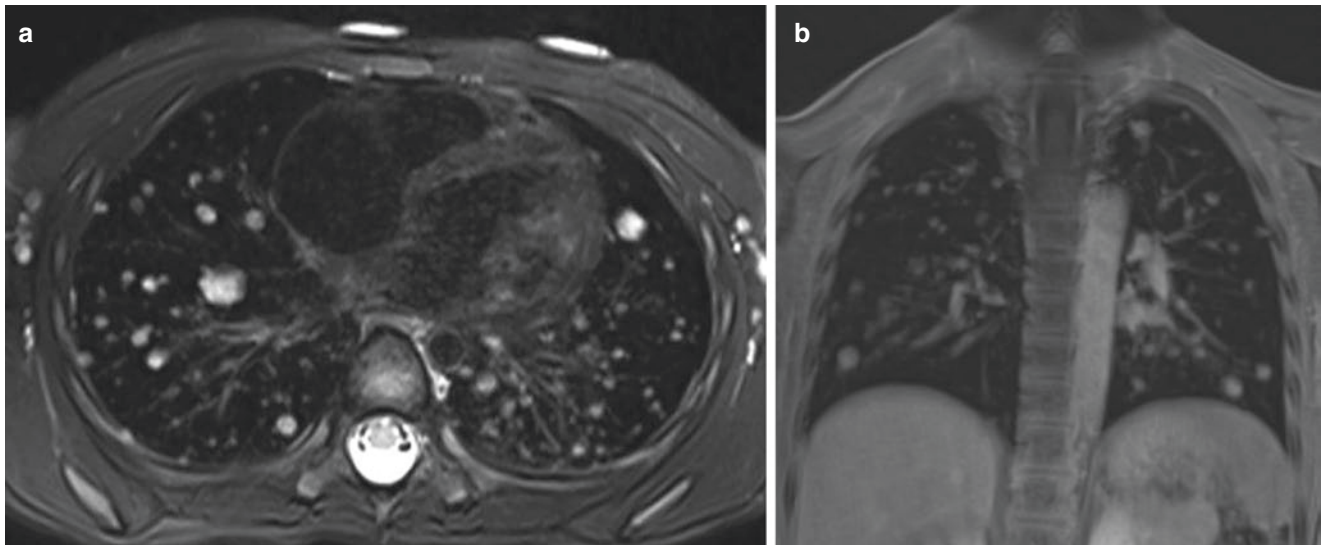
Pulmonary coccidioidomycosis infection in a 5-year-old girl who presented with fever, cough, and headache. (a) Axial non-enhanced T2-weighted fat-suppressed MR image shows numerous bilateral
